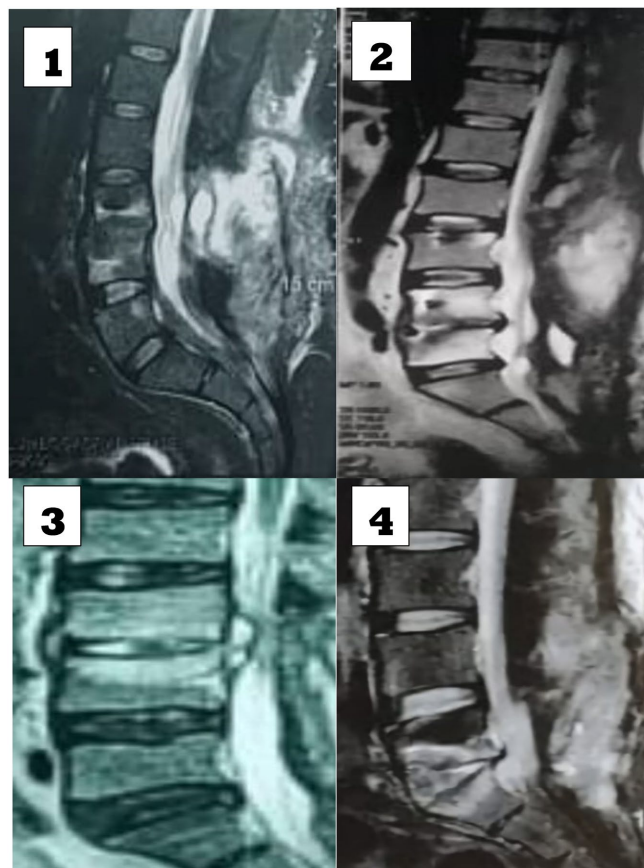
Showing sagittal T2 MRI lumbosacral spine 4 cases. Case 1: showing culture negative L3-4 POSD; Case 2: showing E-coli culture positive L4-5 POSD; Case 3: showing S-aureus culture positive L3-4 POSD with epidural abscess; Case 4: showing culture negative L5-S1 POSD.
